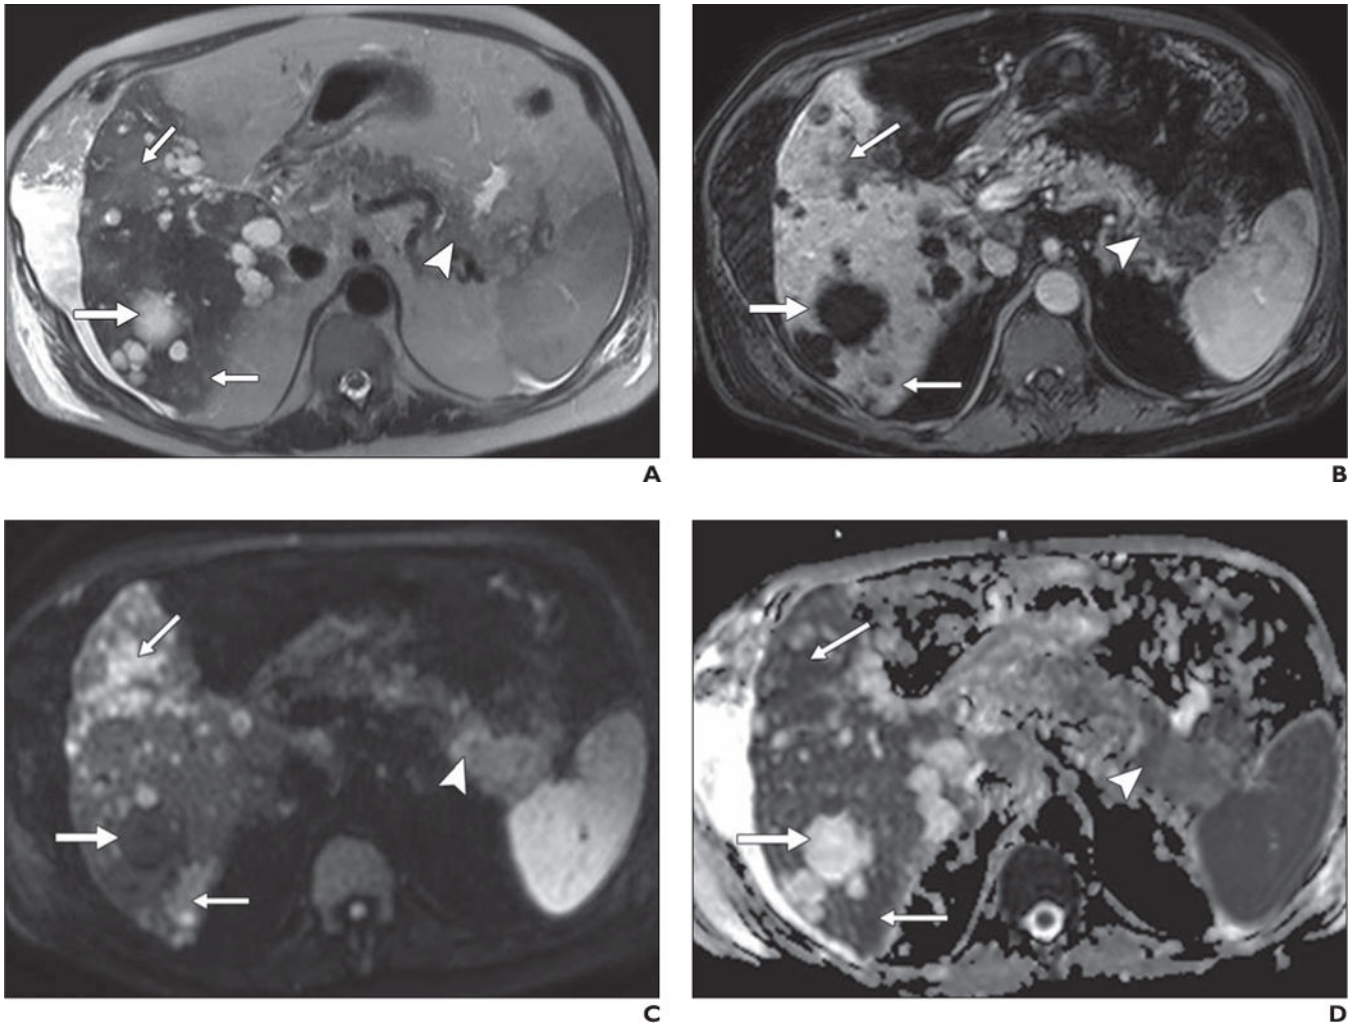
67-year-old man with history of polycystic kidney disease and T3N_xM_x gallbladder cancer. A–D, In T2-weighted single-shot fast spin-echo image (A), gadolinium-enhanced T1-weighted spoiled gradient-echo image obtained during venous phase (B), diffusion-weighted image with b800 (C), and apparent diffusion coefficient (ADC) map (D), mass is seen in tail of pancreas (*arrowhead*), which was biopsy-proven to be adenocarcinoma. Numerous well-demarcated lesions are noted in liver (*thick arrow*) with homogenous high signal intensity on T2-weighted images, low signal intensity on diffusion-weighted b800 images, and high signal intensity on ADC map; these are consistent with simple cysts related to polycystic kidney disease and represent challenge for detection of metastatic disease. Subtle areas of high signal intensity relative to background liver are noted on T2-weighted images (*thin arrows*, A) with mild hypo-enhancement (*thin arrows*, B) but are far more conspicuous on diffusion-weighted image (*thin arrows*, C). Low signal intensity in these lesions on ADC map (*thin arrows*, D) in conjunction with contrast-enhanced images, helps to characterize these as solid lesions. Findings were suspicious for hepatic metastatic disease.
